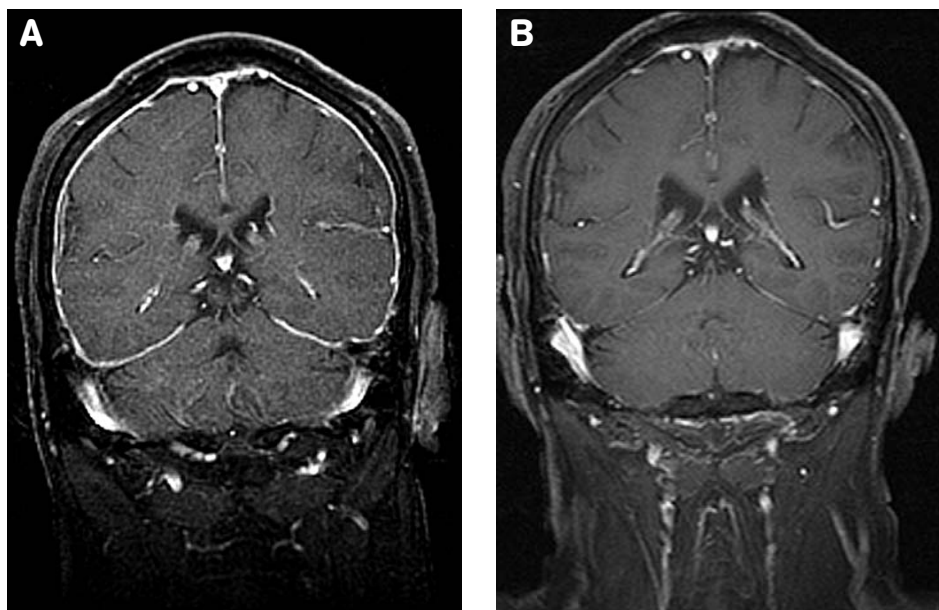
Diffuse pachymeningeal enhancement was shown in the first MRI study (A), which disappeared two months later (B).
